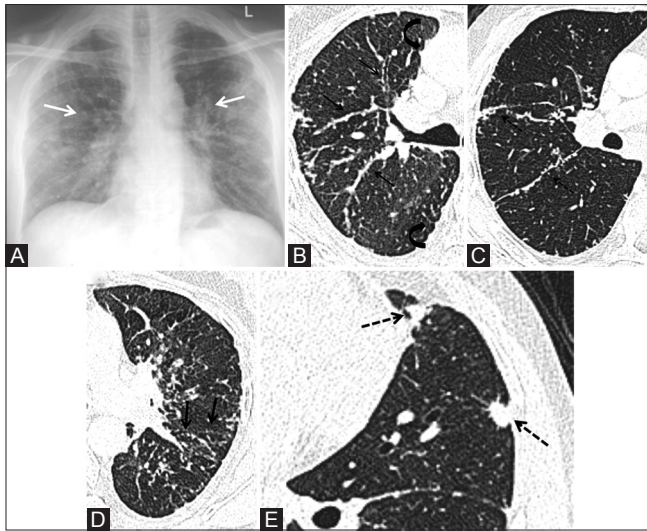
(A-E): Sarcoidosis: Parenchymal nodules. (A) Chest X-ray (CXR) showing bilateral perihilar interstitial nodules, predominantly in upper and mid zones (white arrows). (B, C) Magnified axial high resolution computed tomography (HRCT) images (lung window) in another patient shows typical perilymphatic distribution of micronodules. Discrete rounded well-defined micronodules seen along right bronchovascular bundle (thin arrow), subpleural interstitium (curved arrow), and interlobar fissure (dashed arrows). (D) Magnified axial HRCT image (at lower level) shows sharply defined micronodules along left interlobular septa (thick arrows) (E) sarcoid macronodules. Magnified axial HRCT image (lung window) showing macronodules with irregular margins and multiple peripheral micronodules in left upper lobe representative of coalescent granulomas (dashed arrows). Note discrete perilymphatic nodules along left interlobar fissure
